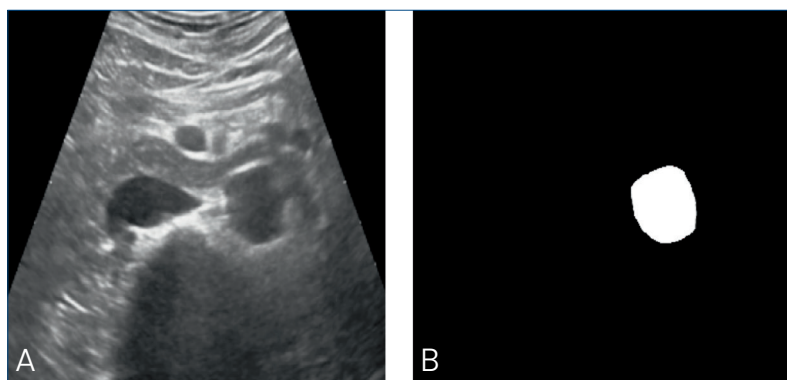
• An ultrasound image of the abdomen (A), the mask manually drawn by the physician to identify the aorta (B)
